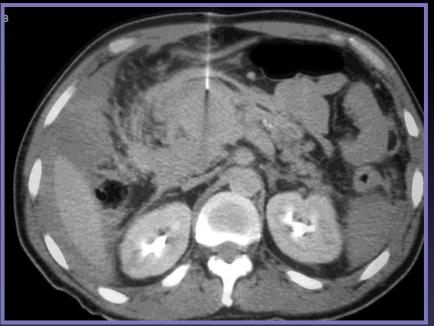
Axial CT pre and post IV contrast. Figure 1a demonstrated a large pseudo-aneurysm centred at the pancreatic head (white arrow). There is significant associated peri-pancreatic Inflammation and free fluid. Figure 2b demonstrates CT a percutaneous thrombin injection to treat the pseudo-aneurysm.
